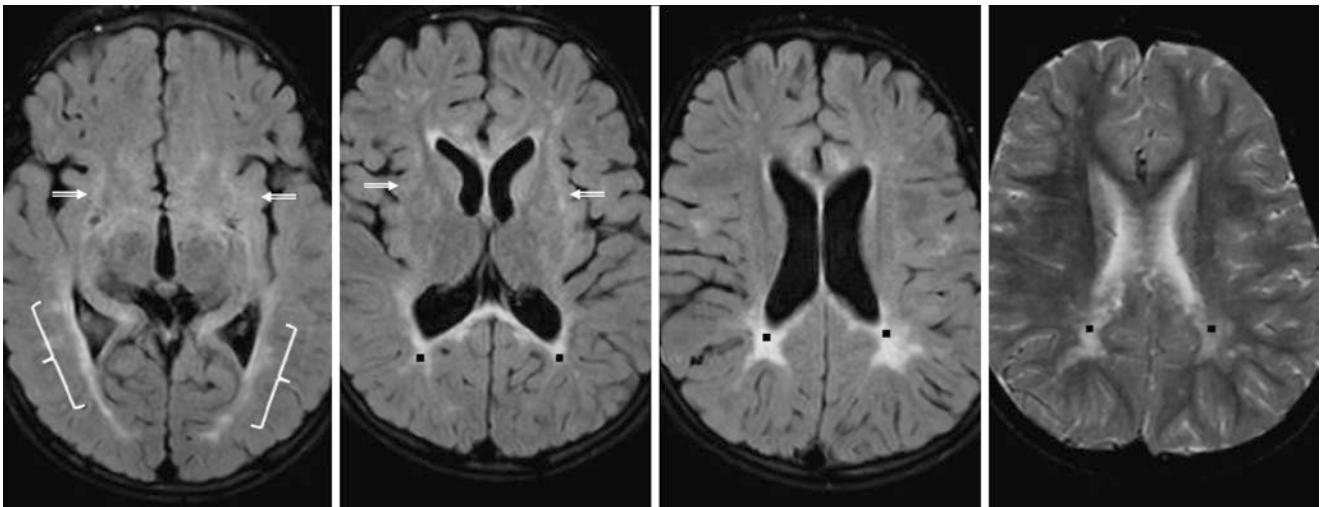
Comparison case of Langerhan's cell histiocytosis (LCH, *i.e.*, eosinophilic granulomatosis). A 5-year-old with LCH underwent several rounds of chemotherapy over 2 years. A 3T MRI showed hyperintense optic radiations (*brackets*), SIWM (*beveled arrows*) and PTWM
